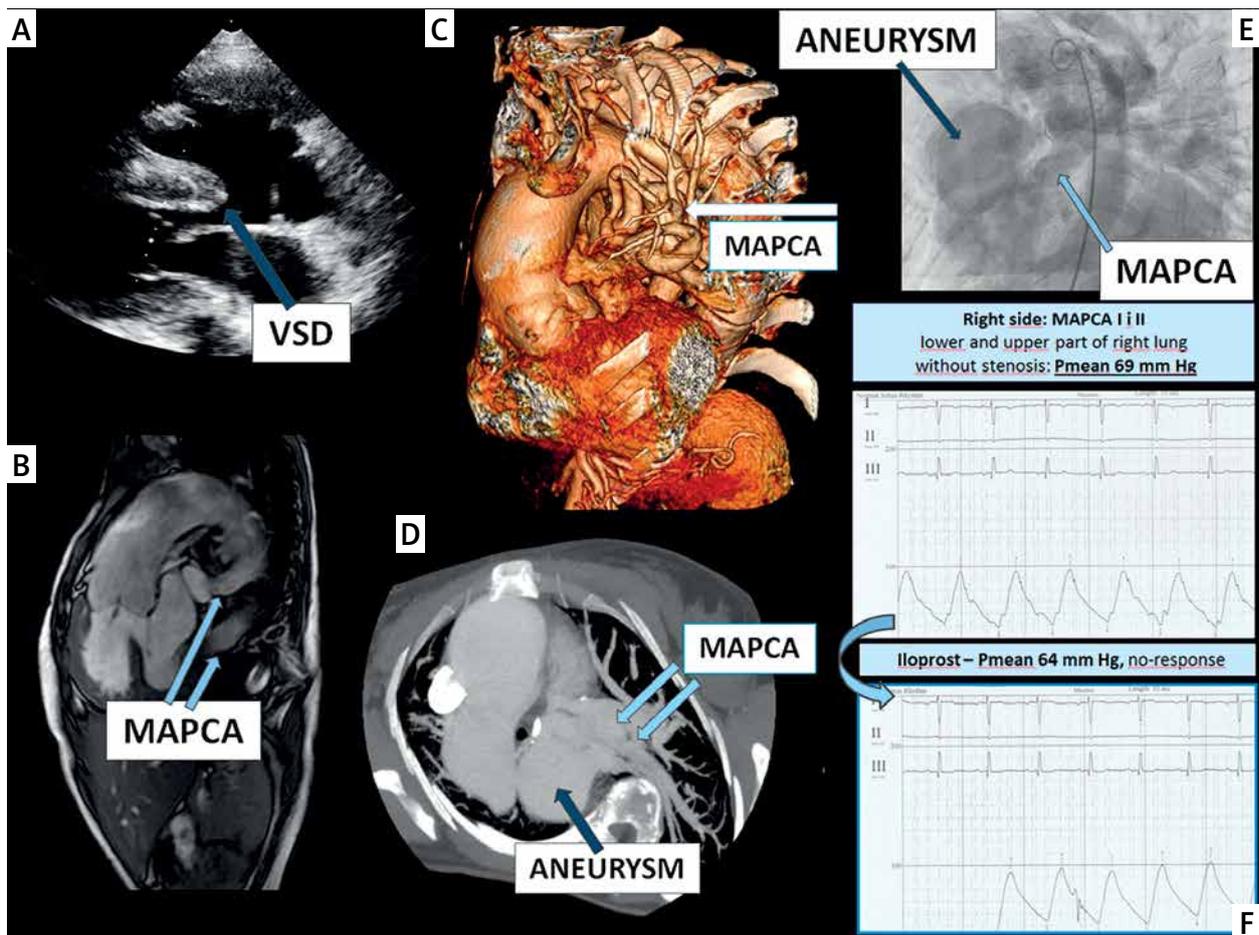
Multimodality imaging: A – transthoracic echocardiography – parasternal long axis view, arrow: large VSD; B – CT scan, arrows: MAPCAs; C – CT scan, 3D reconstruction, arrow: MAPCA; D – CT scan, arrows: MAPCAs, arrow: large aneurysm; E – angiography, arrows: MAPCA, aneurysm; F – vasoreactivity test with no response for iloprost
